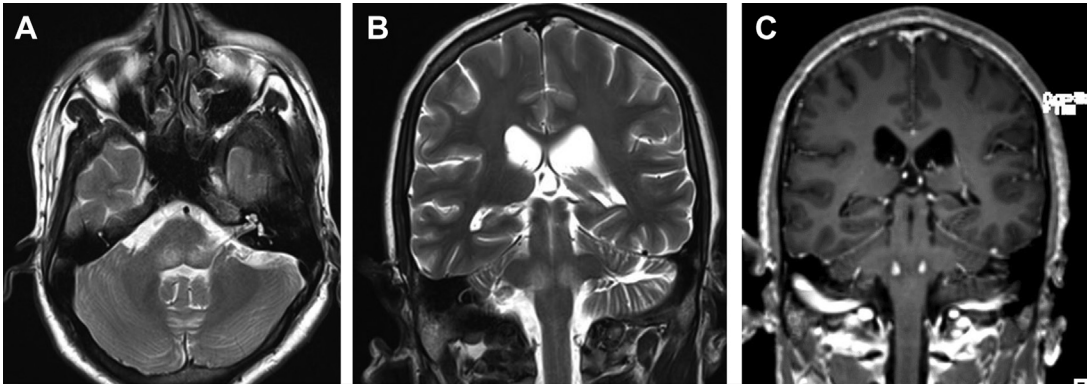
CNS leprosy. Axial T2-weighted MR imaging (A) and coronal T2-weighted MR imaging (B) show symmetric T2 hyperintensities in the dorsal pons with corresponding contrast enhancement (C).
